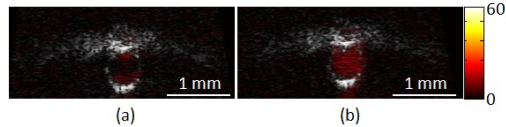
Coregistered ultrasound images (gray scale) with photoacoustic images (red scales). Images show cross sectional view of a plastic tube filled with (a) pure de-ionized water or (b) de-ionized water with carbon nano particles. Note that The scale of colorbar is dB.
